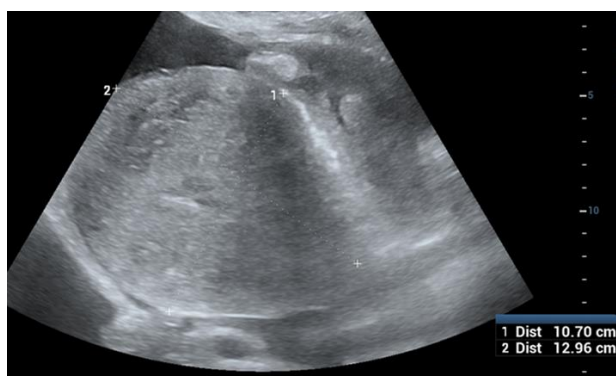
Abdominopelvic ultrasound: Finely echogenic great abundance peritoneal and pelvic effusion, with a globular uterus, without visualized myometrial defect
